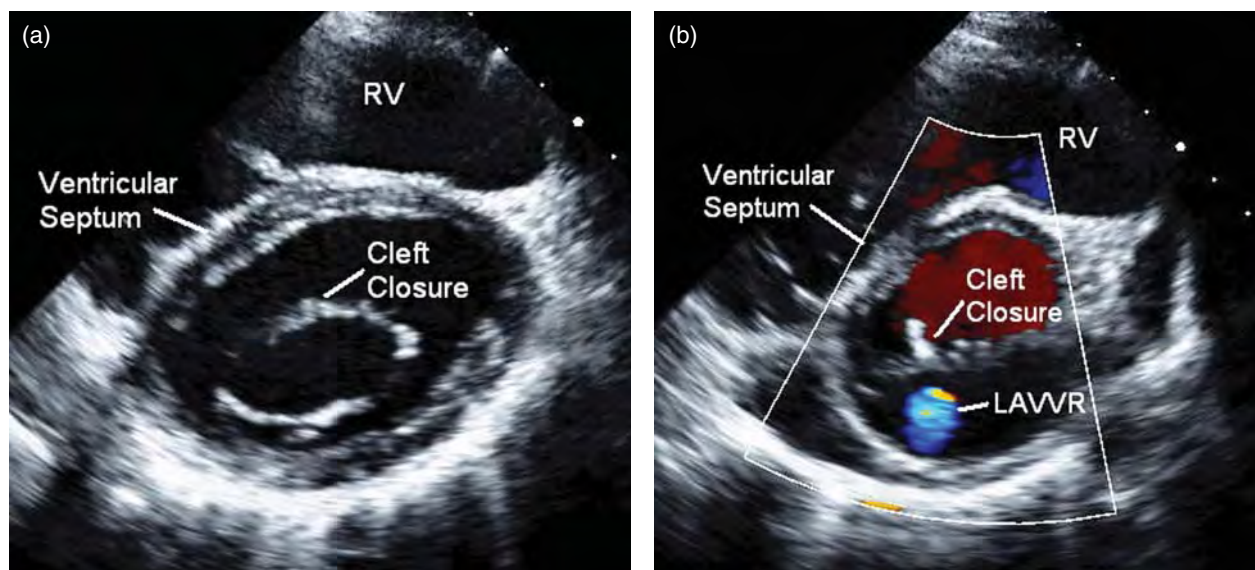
(a) Parasternal short-axis view of a patient with complete common atrioventricular canal who has undergone repair including closure of the cleft in the left atrioventricular portion of the valve. The region where the superior and inferior bridging leaflets are sewn together is highlighted. (b) Image using color Doppler in the same patient. There is a trivial jet of residual atrioventricular valve regurgitation seen at the edge of the cleft closure. LAVVR, left atrioventricular valve regurgitation; RV, right ventricle.
